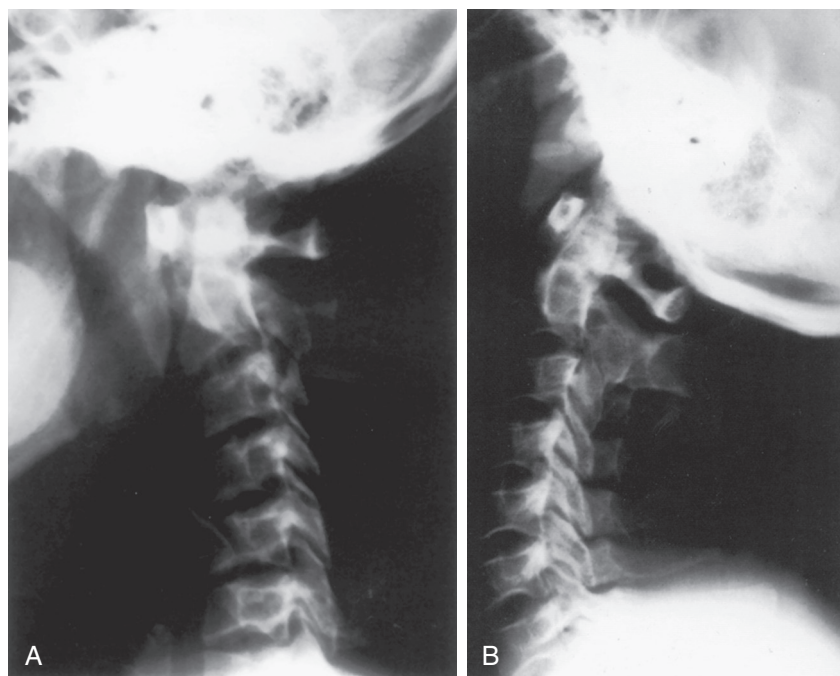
A, Plain lateral cervical spine radiograph in flexion showing ventrolisthesis of C1 on C2. B, Plain lateral cervical spine radiograph in extension showing reduction of the subluxation.
